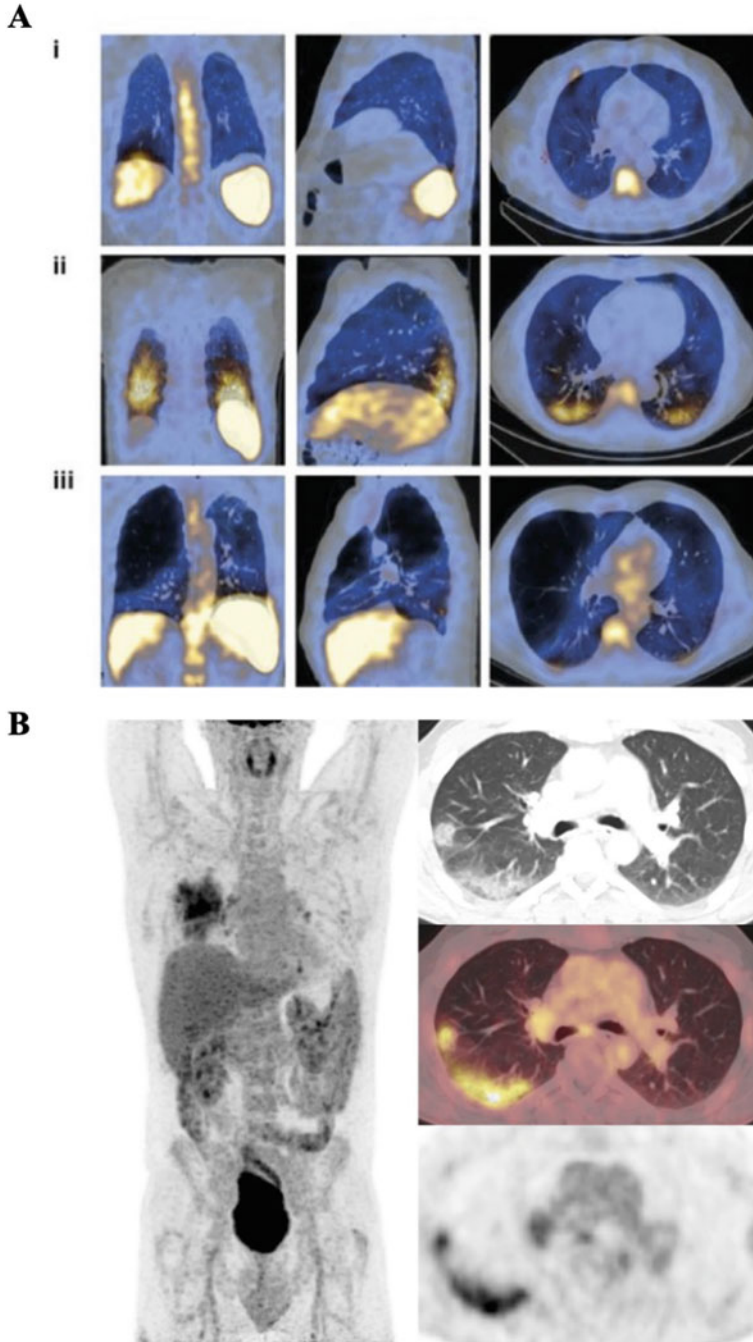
White blood cell scintigraphy or SPECT/CT and [^{18}F]FDG PET/CT are routine clinical imaging techniques used for imaging different biological processes in infections and inflammatory disorders. (a) SPECT imaging of [$^{99\text{m}}\text{Tc}$]Tc-HMPAO-radiolabelled autologous neutrophils has been used in experimental medicine studies for studying chronic obstructive pulmonary disease
